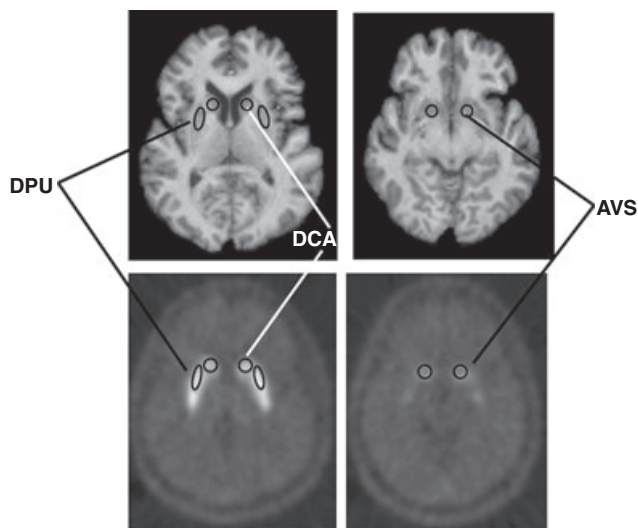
Location of the MRI-based ROIs defined *a priori* in the putamen, caudate and anteroventral striatum (after Drevets *et al.*, 2001). Regional PET measures were extracted from each ROI and compared between conditions. DPU, dorsal putamen; DCA, dorsal caudate; AVS, anteroventral striatum.
